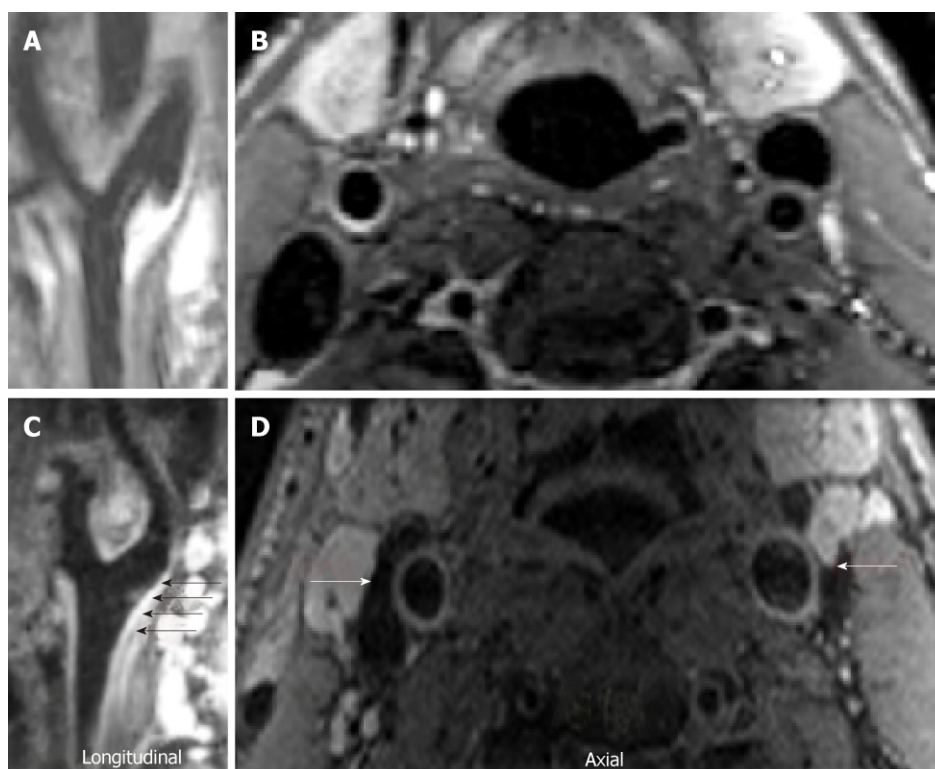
Dark blood magnetic resonance imaging images. A, B: Healthy vessel in a control subject; C, D: Increased carotid wall thickness (arrows) and area in a cocaine addicted individual. A and C show longitudinal images of the left carotid bifurcation. B and D show axial images of the lateral carotid.
